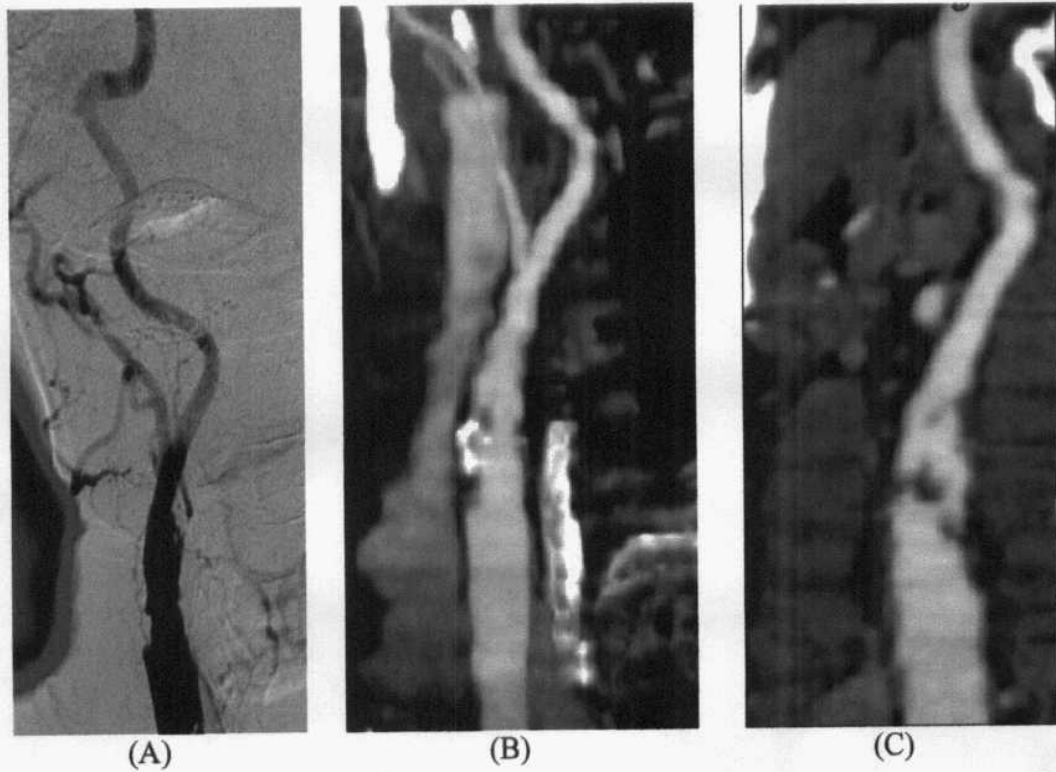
Right internal carotid artery stenosis by DSA (A), MIP(B), curved reformat(C), axial CT reformat (D), and color flow duplex (E)
